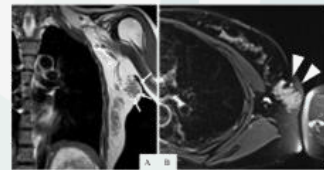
MRI of left axillary area. (A) Coronal view of T2-weighted image reveals an isodense lesion in the left axillary area, and its appearance is similar to that of normal breast structure (arrows). (B) Axial view of T2-weighted and fat-suppressed image reveals high-density lesion (arrowheads), which is compatible with the findings of accessory breast tissue.
